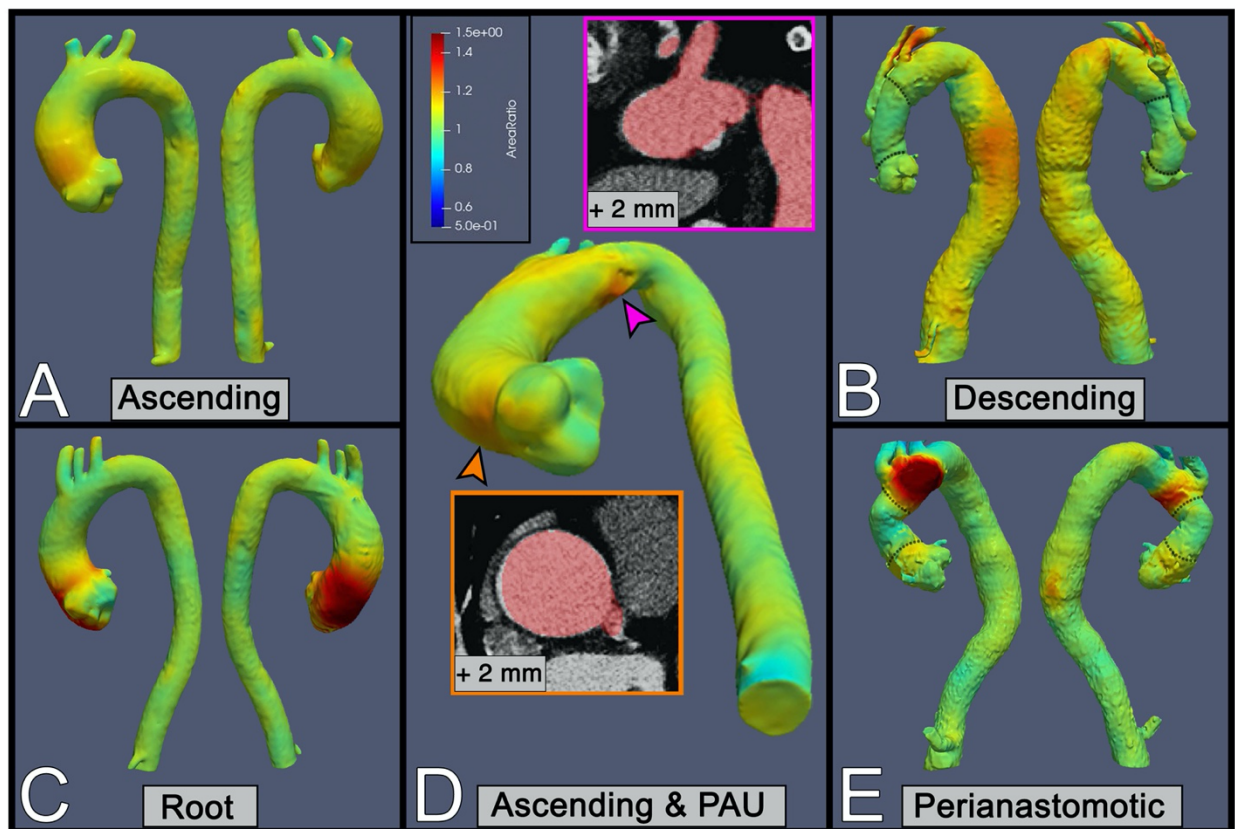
Examples of TAA growth patterns identified by VDM in a clinical cohort of patients undergoing CTA imaging surveillance. Representative examples of ascending aortic growth involving the tubular segment (A) and root (B), as well as post-surgical growth involving the descending aorta (B) and perianastomotic region in the arch (E); black dotted lines depict surgical graft anastomoses. Six intervals demonstrated growth in locations other than the primary aneurysmal segment, for example an enlarging penetrating ulcer was noted in the arch of a patient with a growing ascending aneurysm (D). Red masks depicting the baseline anatomy are overlaid on follow-up CT scans after rigid registration to allow for visual depiction of growth.
